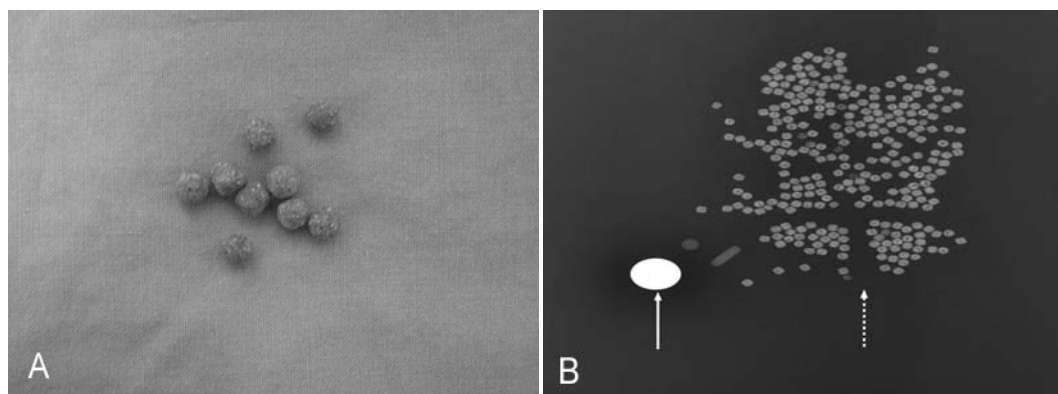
(A) Herb medicinal pills. The amount of lead contained in herb medicinal pills was assayed : 2,612 $\mu\text{g/g}$ (thetolerance dose of crude drug is 30 $\mu\text{g/g}$). (B) A simple X-ray of herb medicinal pills (solid line : coin, dotted line : herb medicinal pills).
